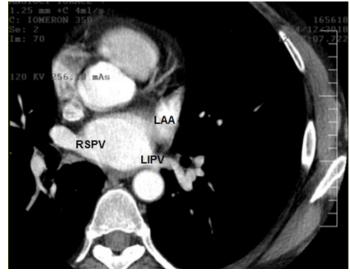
Computed tomography of the heart. Left atrial appendage, right superior pulmonary vein and left inferior pulmonary vein. LIPV has a posterior orientation and RPSV has an anterior orientation.
